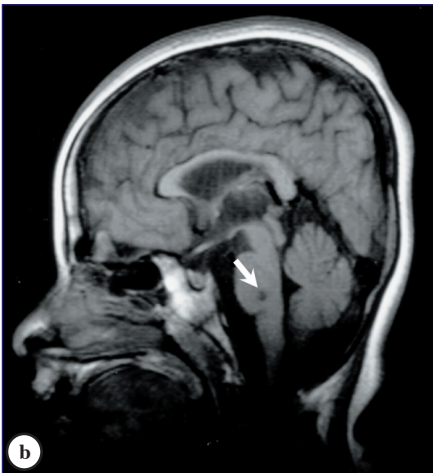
a) Axial brain CT showing bilateral symmetric large low attenuation thalamic lesions due to infarction (arrows). b & c) Three years follow-up MRI showing regression of the thalamic lesions. Residual high signal intensity on coronal T2-weighted image (arrows in c) is seen in the thalamic region, bilaterally. Small central old pontine infarction appears as low signal on sagittal T1-weighted image (arrow in b) and high signal on coronal T2-weighted image (open arrow in c).
